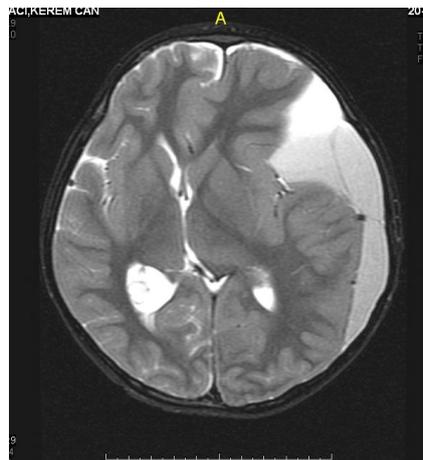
MRI shows left chronic subdural hematoma and intracystic hematoma including left middle cr.
